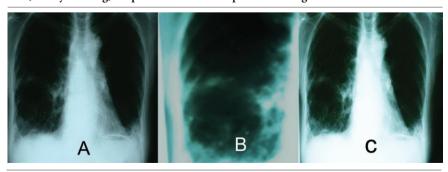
Posterior-anterior chest radiograph on the first day of the patient's presentation at our Center still showing bronchiectasis, honeycombing in the both lower lobes and bilaterally pleural effusion (A,B) with a new huge-thin-wall cavity in the right lower lobe (A,C), which spontaneously resolved 2 months later (C).
